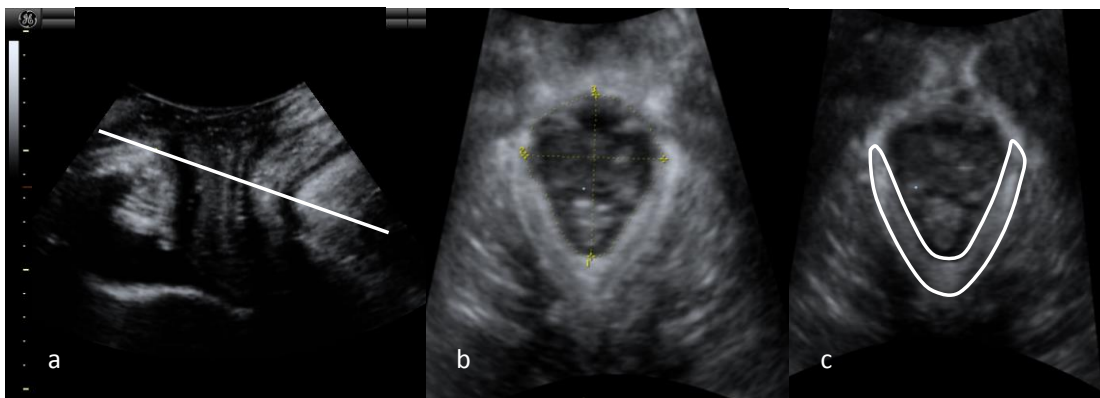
Translabial pelvic floor ultrasound, in the mid-sagittal plane, showing the plane of minimal *hiatal* dimensions (a). In (b), measures of *levator hiatus* area, AP and RL diameters at rest are depicted. In (c), the area of pubovisceral muscle is measured to calculate the MOI.
